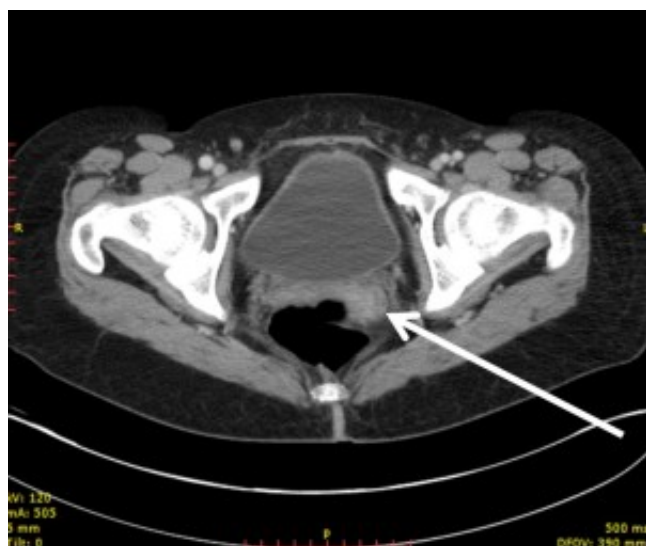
Computed tomography of the pelvis in a patient with morcellation of the uterine leiomyosarcoma two months prior to definitive cytoreductive surgery with hyperthermic intraperitoneal chemotherapy and early postoperative intraperitoneal chemotherapy. A 1.6 cm soft tissue mass is demonstrated on the left pelvic sidewall anterior to the hypogastric vessels. This was not apparent on prior studies. At surgery, it was confirmed as a nodule of leiomyosarcoma.
